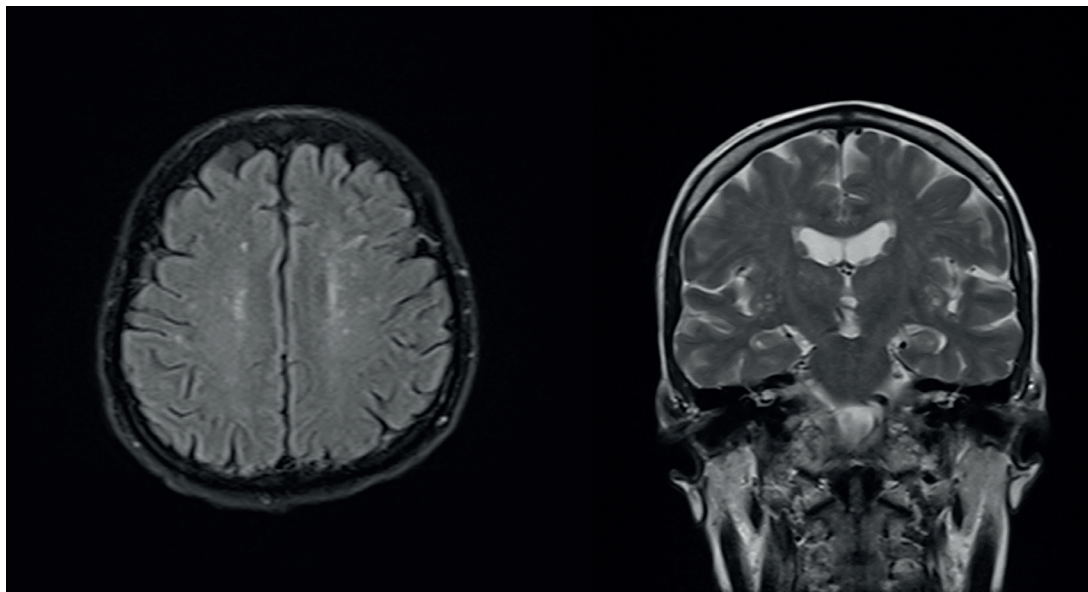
Magnetic resonance imaging of 51-year-old Male Known Case with 16 Years Involvement with psoriasis. Mild periventricular and subcortical T2-weighted hyper signal lesions are seen due to small vessel disease (arrows)
